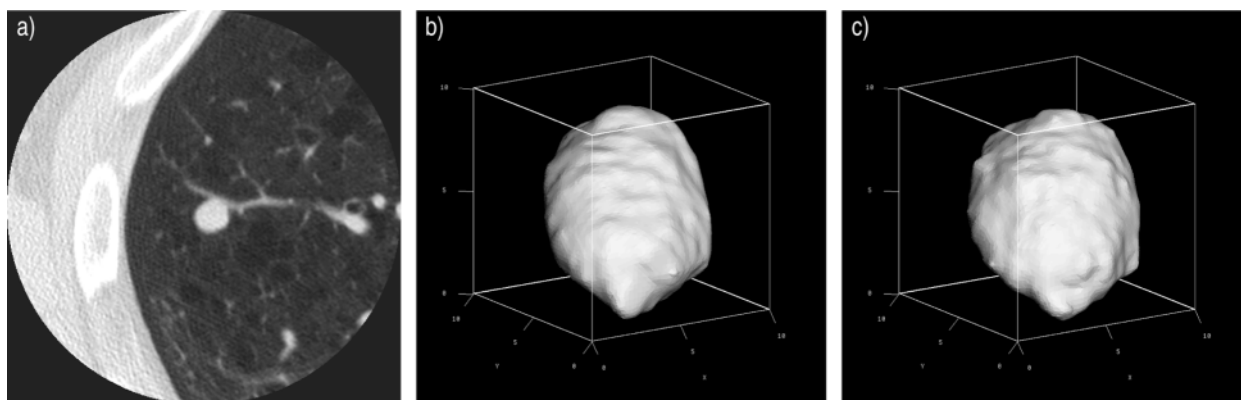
An 8-mm pulmonary nodule detected on baseline screening. a) High-resolution computed tomography (CT) of nodule in right upper lobe. The nodule volume (b) was compared to that measured on a subsequent high-resolution CT scan taken 6 months later (c). The nodule doubling time was estimated to be $>3,000$ days, clearly indicating stability and likely benignity.
